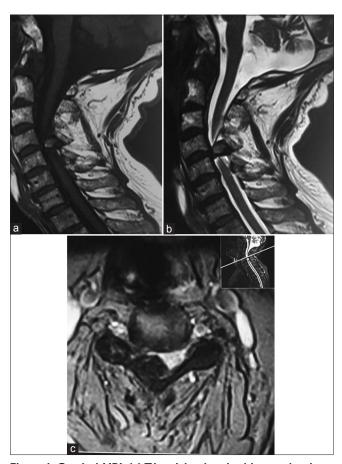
Cervical MRI: (a) T1-weighted sagittal image showing a heterointense epidural mass at the posterior aspect of the spinal cord at the C4-C5 level, a smaller one is visualized below this level. (b) T2-weighted sagittal image demonstrating a hypointense mass with an isointensity at the center of the mass. (c) It also reveals a significant reduction in the cervical canal diameter
